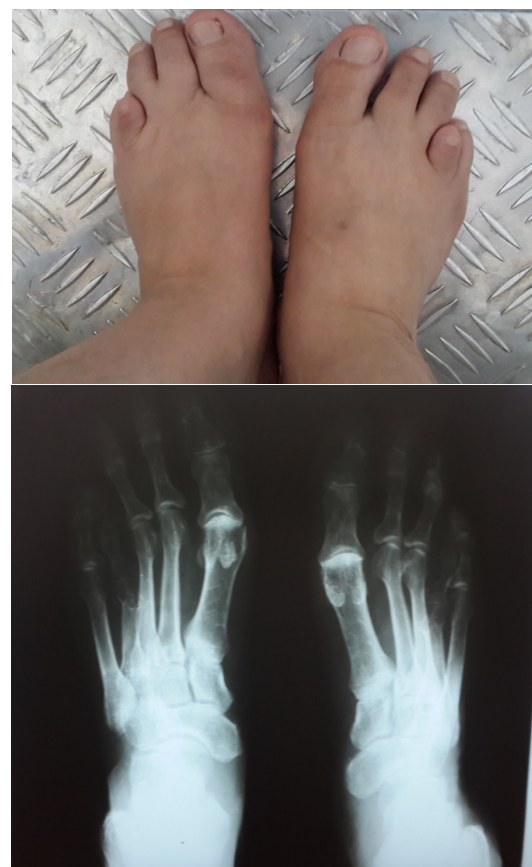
Radiography of her feet
